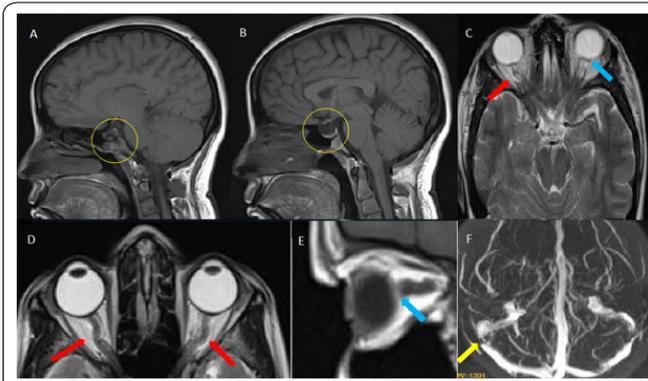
Neuro-Imaging in IIH. A-B: MRI Sagittal FLAIR images showing empty sella; C-D: MRI axial cuts showing tortuous and distended optic nerves (arrows); E: MRI orbit sagittal cuts showing flattening of posterior part of globe and tortuous optic nerve; F: MRI venogram showing right transverse sinus stenosis (arrow).
